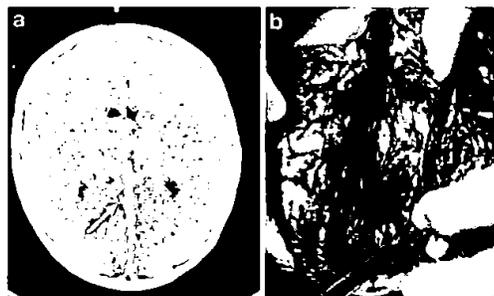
Intrafalcine bleeding. a CT scan shows interhemispheric high signal which was interpreted as SDH. b Autopsy demonstrated all of the bleeding to be intradural in the posterior falx. Four months baby, sudden death with pyrexia and brain swelling. No evidence of trauma
